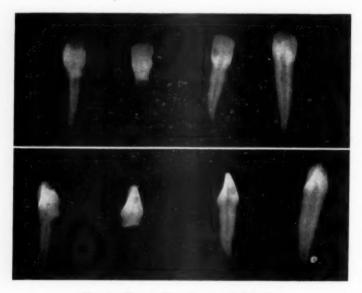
X-ray film of extracted teeth.
